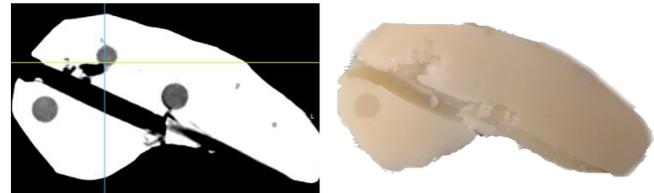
Pancreatic resection marks (CT, left; midline cut, right)
